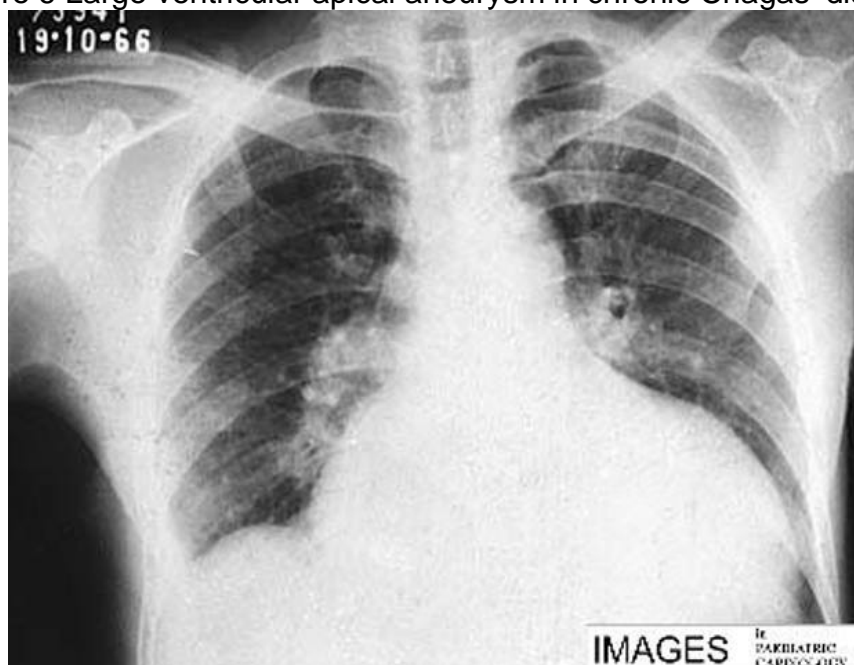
X-ray of chest showing global cardiac enlargement
